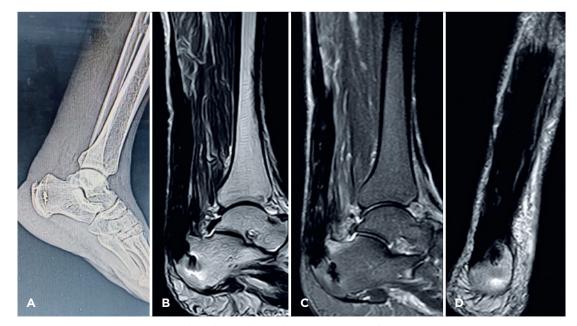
One year postoperative; Lateral ankle radiograph (A) shows restoration of TA continuity to its insertion via an inserted anchor. Sagittal T1 (B), sagittal fat suppression (C), and coronal (D) MRI slices reveal restoration of TA continuity with increased diameter.
